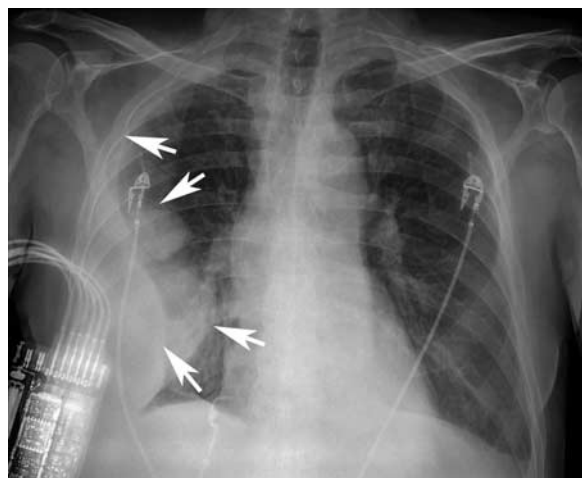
Empyema due to *Staphylococcus aureus*. Posteroanterior chest radiograph of a 67-year-old man shows large multiloculated right pleural effusion (arrows). There is no radiologic evidence of septic embolism.
